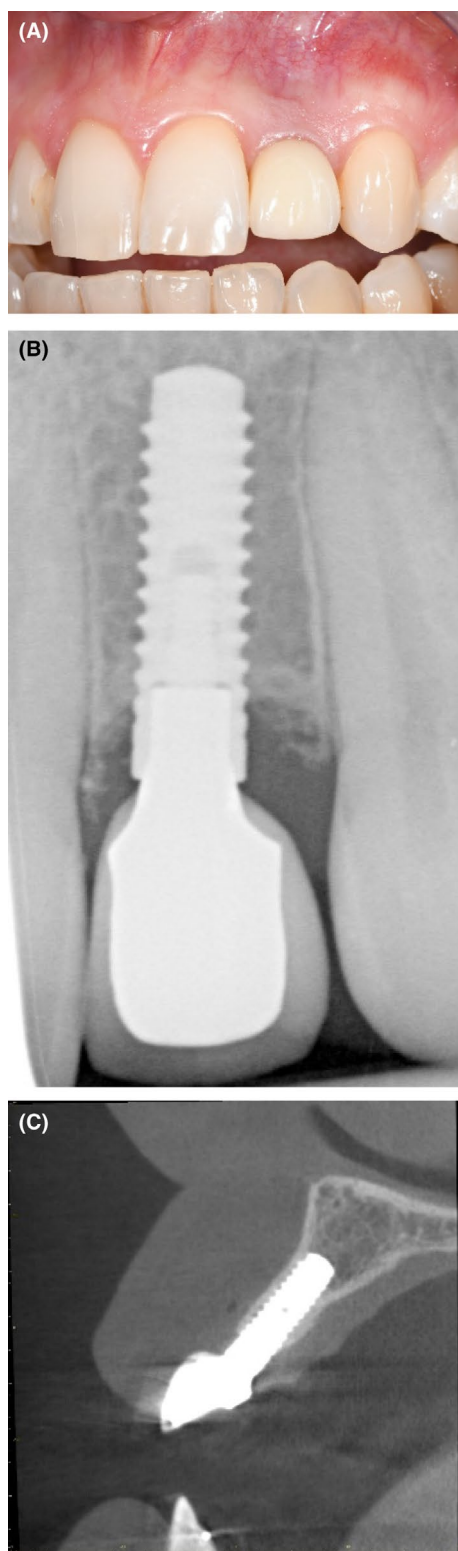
(A) The implant in the maxillary left lateral incisor site is in a coronal malposition, that is, it has been placed too superficially. (B) The periapical radiograph shows crestal bone loss and an overcontoured crown. (C) The corresponding parasagittal CBCT view of the implant shows crestal bone loss on the buccal and palatal aspects of the implant.
